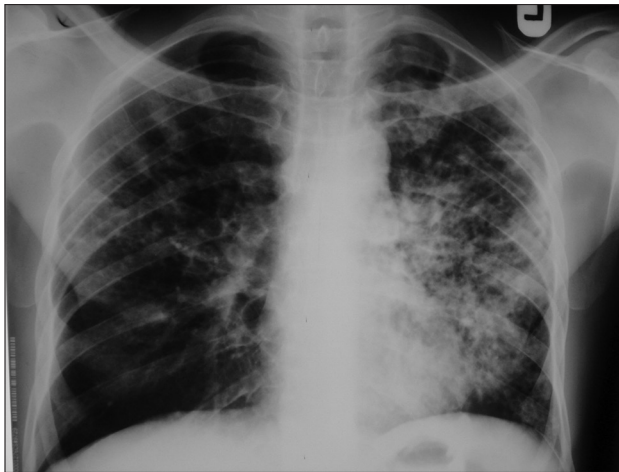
P.A chest radiograph of HIV/PTB ARV-naïve patient showing widespread reticulonodular opacities with background cystic changes in both lung fields worse on the left
